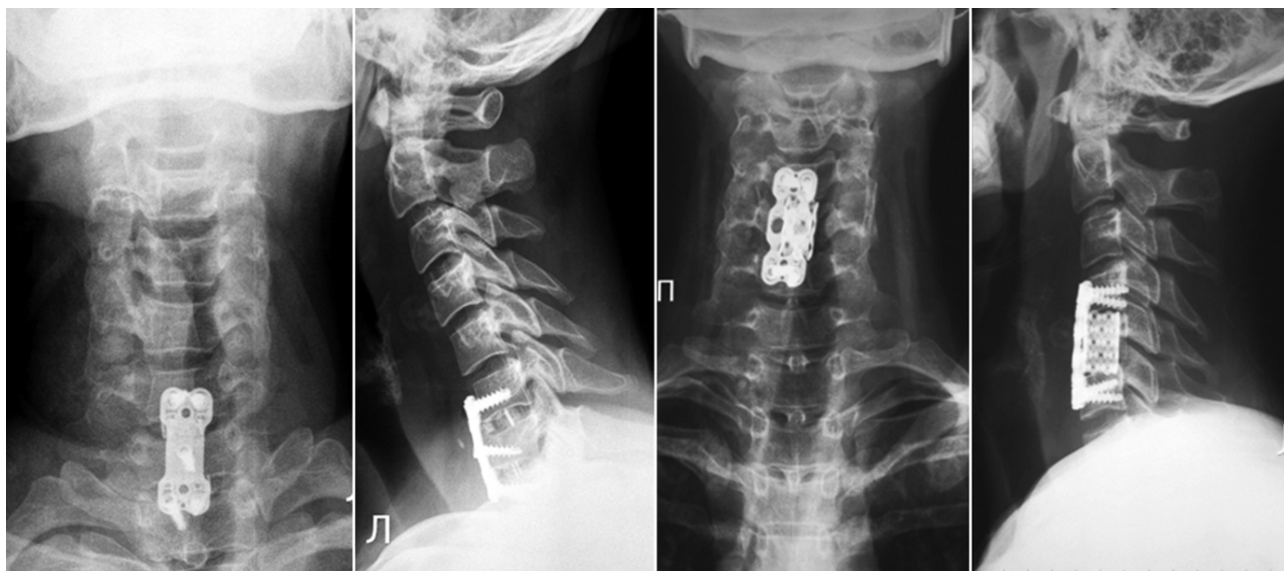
Radiographs of cervical spine showing various types of anterior fixation
